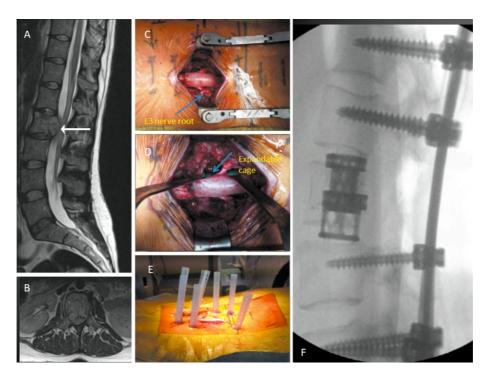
A 32-year-old woman presented with mid back pain and leg weakness over 3 weeks. (A) and (B) MRI images showing solitary L_2 lesion causing circumferential cauda equina compression. (C) Intraoperative photograph showing midline incision with circumferential decompression and vertebrectomy. Decompressed L_3 nerve roots are displayed (arrow). (D) Intraoperative photograph showing expandable cage (arrow) assisted vertebral body reconstruction. (E) Intraoperative photograph showing midline wound closure and percutaneous fixation two levels above and below the vertebrectomy. (F) Post-operative radiograph.
